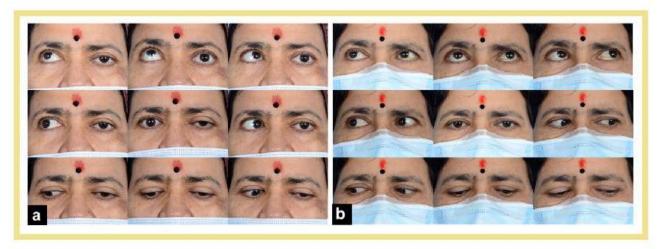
A 56-year-old-lady presented to us with left eye BCVA of light perception only, ptosis of 3mm, restriction of movements in all directions with radiological evidence of involvement in the supero-medial and inferomedial aspect. She was diagnosed to have stage 3b ROCM. Figure 3b: After a series of 7 injections of trans-cutaneous retro-orbital Amphotericin B (1mg/ml), she had complete resolution of symptoms and signs along with BCVA of 20/40 at the latest follow-up 5 months and interval decrease in the medial orbital involvement on MRI. (Courtesy – Honavar et al¹¹)
